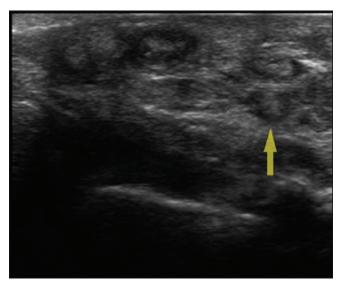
"Dot-in-circle" sign on ultrasound (Yellow arrow) (Case 2).
